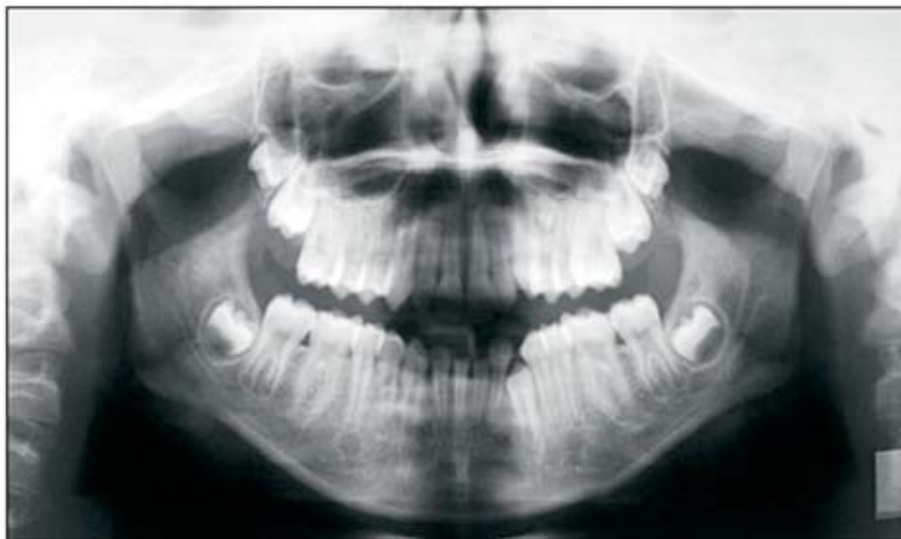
First panoramic radiograph of the patient at age 11 years showing the presence of three supernumerary teeth in both maxillary premolar regions and mandibular right premolar region.
